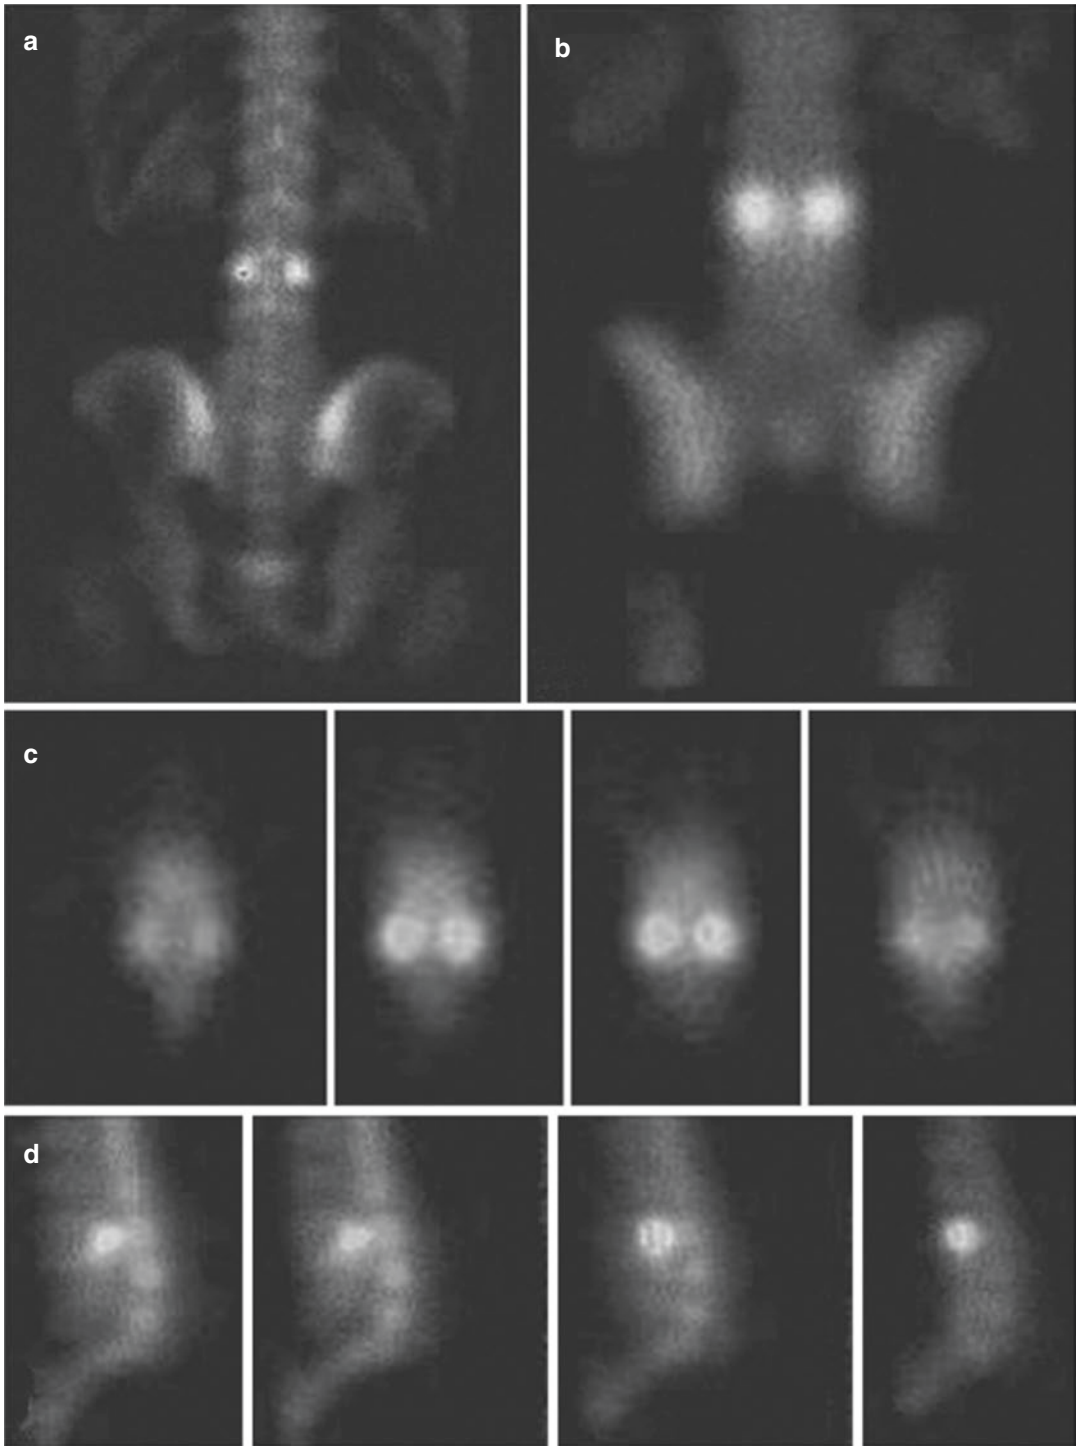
(a–d) Planar (a), representative coronal cut (b), transaxial (c), and sagittal (d) cuts of SPECT study of a young male athlete complaining of low back pain. The
